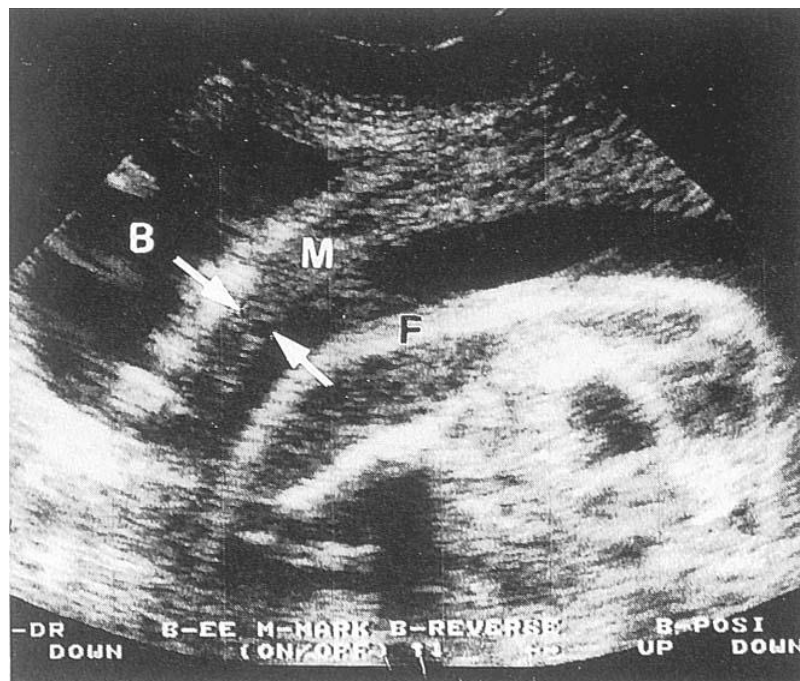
( 7) Sonogram of patient showing normal symmetrical thickness of myometrium between the arrows. B, bladder, M, myometrium; F, Fetus.
